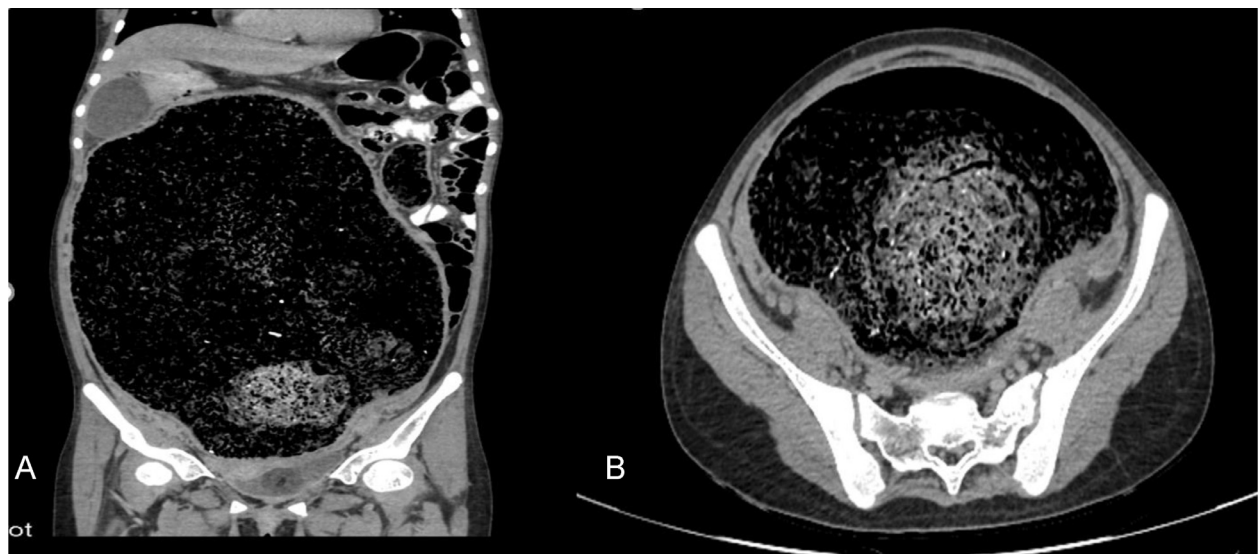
Coronal (A) and axial CT scan (B) section shows grossly dilated sigmoid colon with fecal component within. Also, the dilated colon is seen compressing and displacing surrounding structures.
